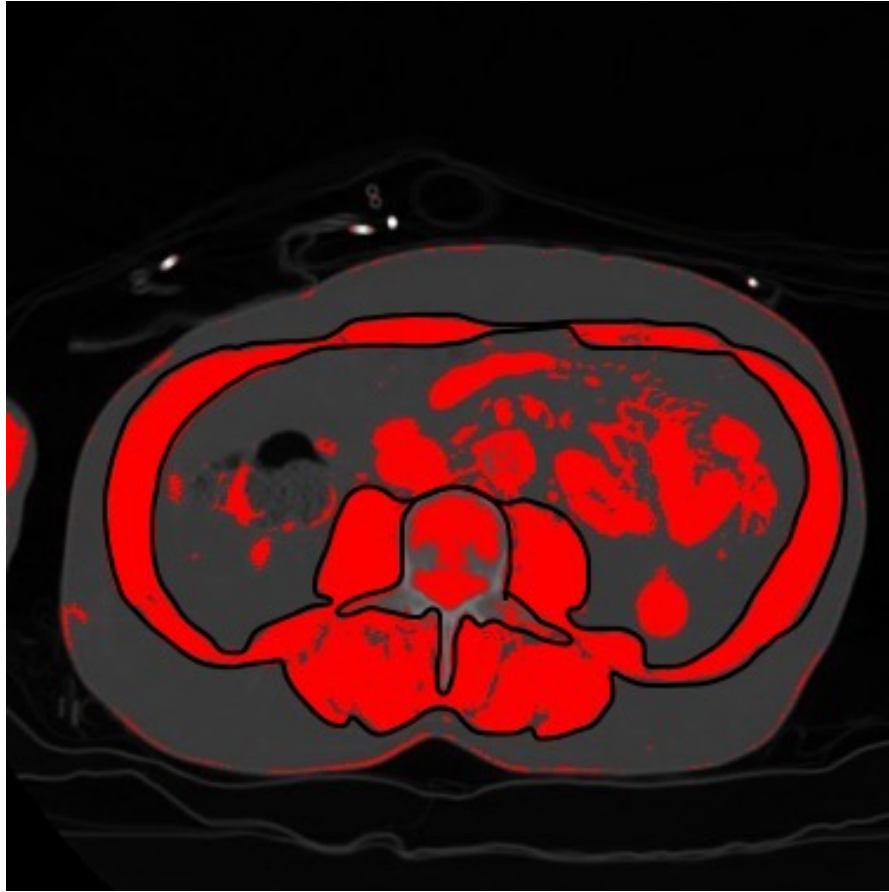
Outline of total skeletal muscle area at the level of the third lumbar vertebra on CT imaging using ImageJ. To calculate the total skeletal muscle area, the area outlining the vertebral head and inner abdominal muscle layer was subtracted from the area outlined by the outer abdominal muscle layer.
